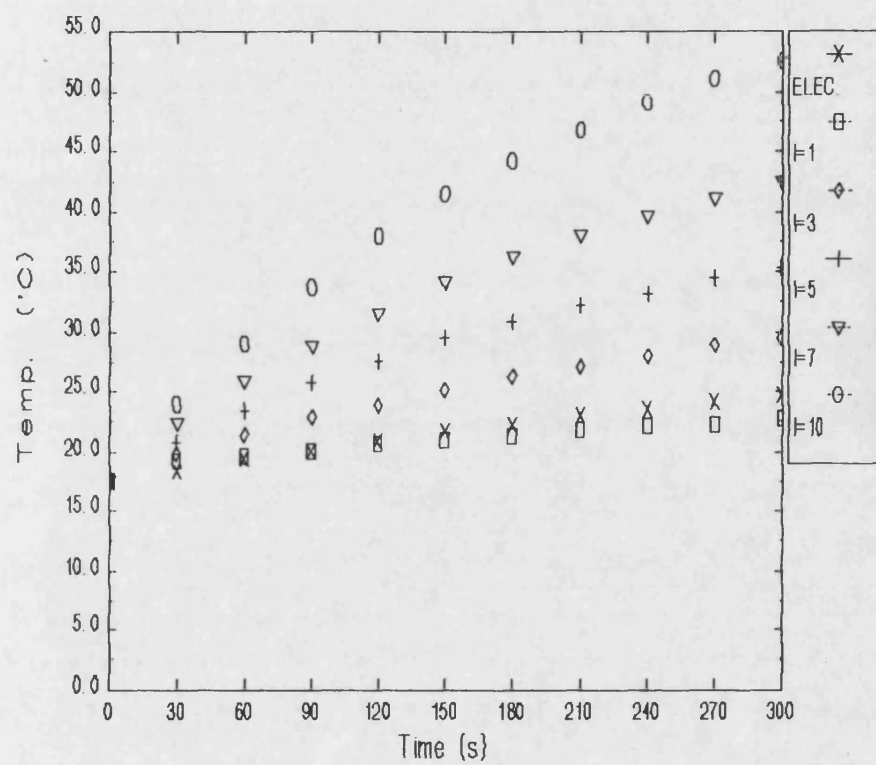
Calibration of the VC600 ultrasonic probe.
